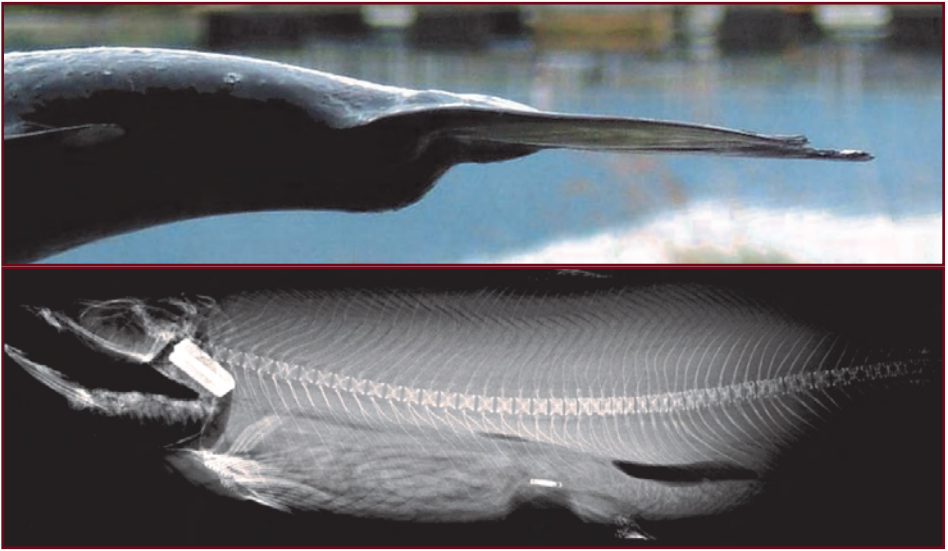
Pathology of long term, subclinical P deficiency in *A. salmon*: b) broken tail axis induced by low P in juvenile rearing, c) X-ray image of 4 kg salmon fed a diet deficient in P and Zn in freshwater rearing.
